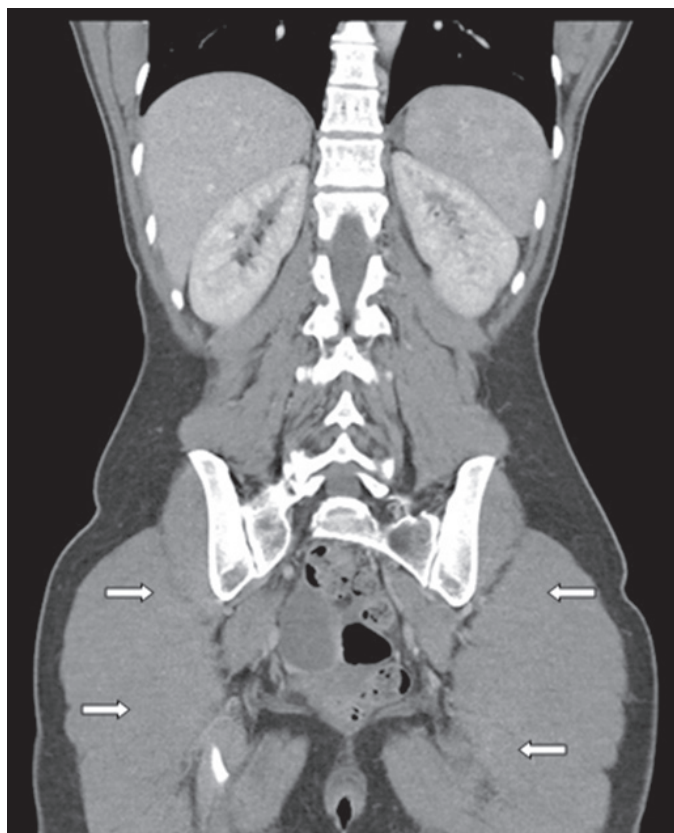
Coronal computed tomography imaging of patient, six months into treatment. The infection, previously present in the ovaries and pelvis, has resolved.
